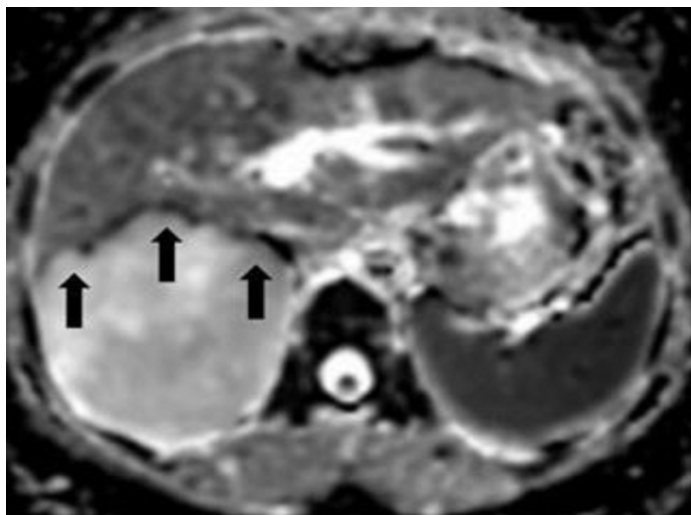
Axial ADC map image on MRI shows a hypointense rim (arrows) in the area where the giant hemangioma is adjacent to the liver parenchyma
